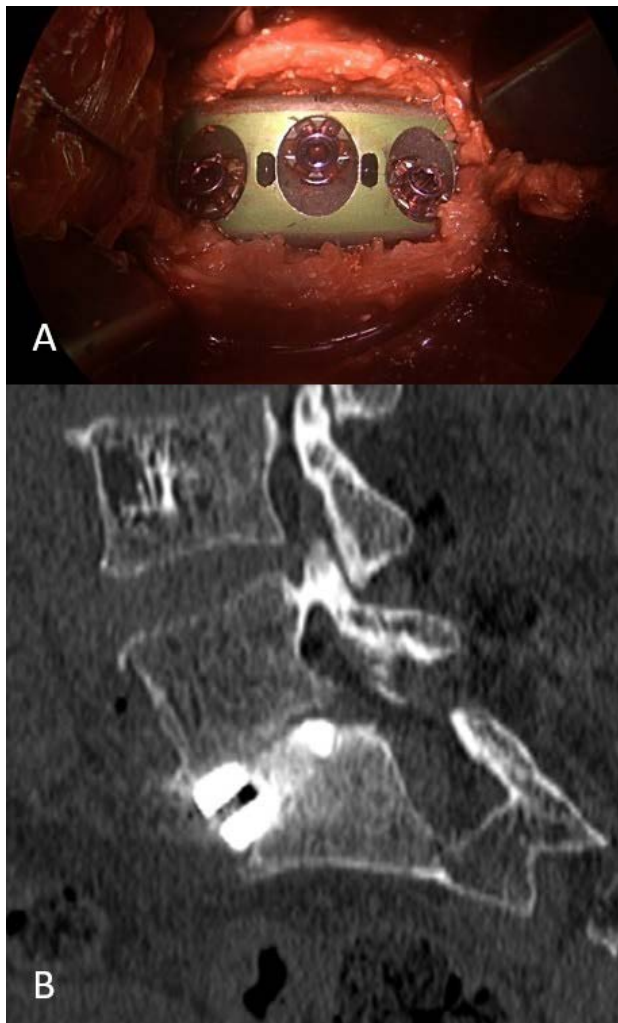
A: Endoscopic view and magnification showing lordotic shape (15°) titanium cage filled by heterologous bone substitute implanted after endplates preparation and mobilization of the two vertebral bodies. The posterior wall of the disc space has been decompressed. B: Post-operative CT scan sagittal view, showing restoring of disc space after lordotic cage implant.
